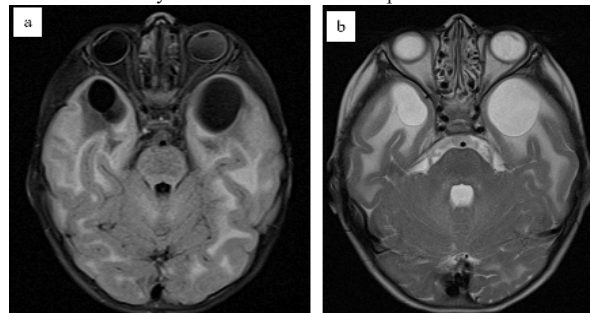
a) and b) FLAIR, T2W axial images shows subcortical cysts in bilateral anterior temporal lobes.
